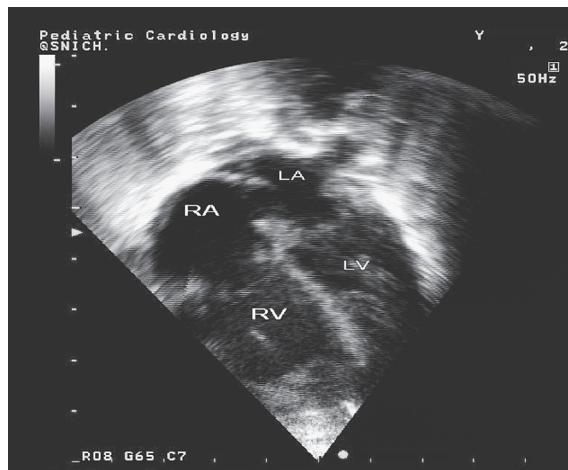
Echocardiogram revealed right atrial and right ventricular enlargement (RA = right atrium, RV = right ventricle, LA = left atrium, LV = left ventricle)
